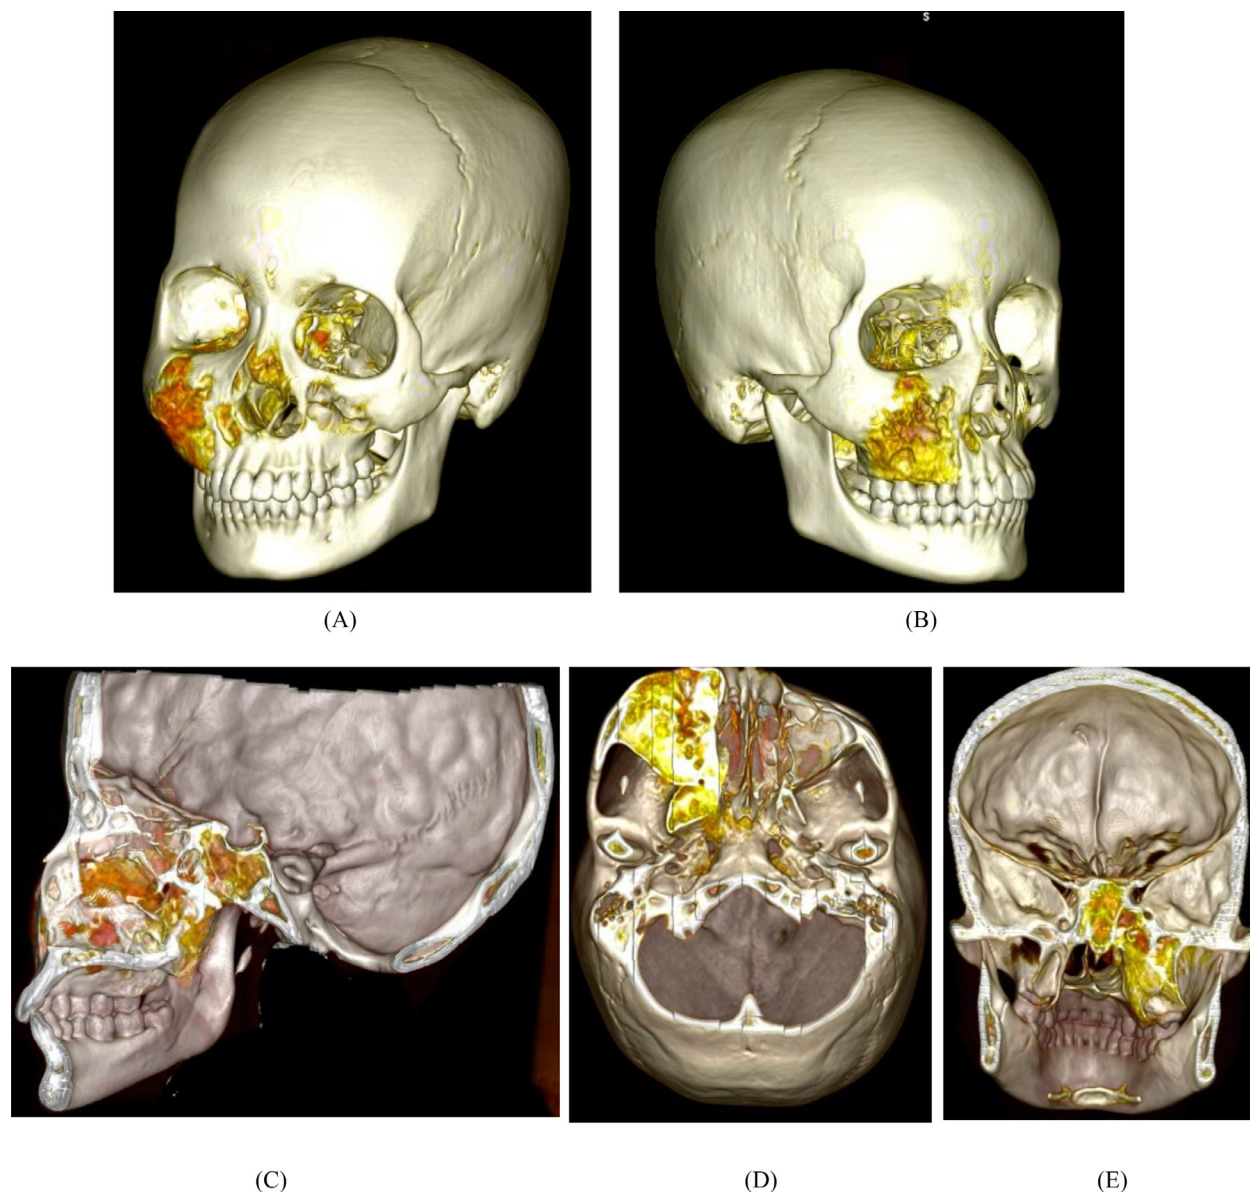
(A-E) Ossifying fibroma. CT scan with 3-dimensional formatted images of the maxilla shows mixed density, well-circumscribed bone extending to the right maxillary and sphenoid sinus, right sphenoid bone, and pterygoid bone into alveolar processes.
